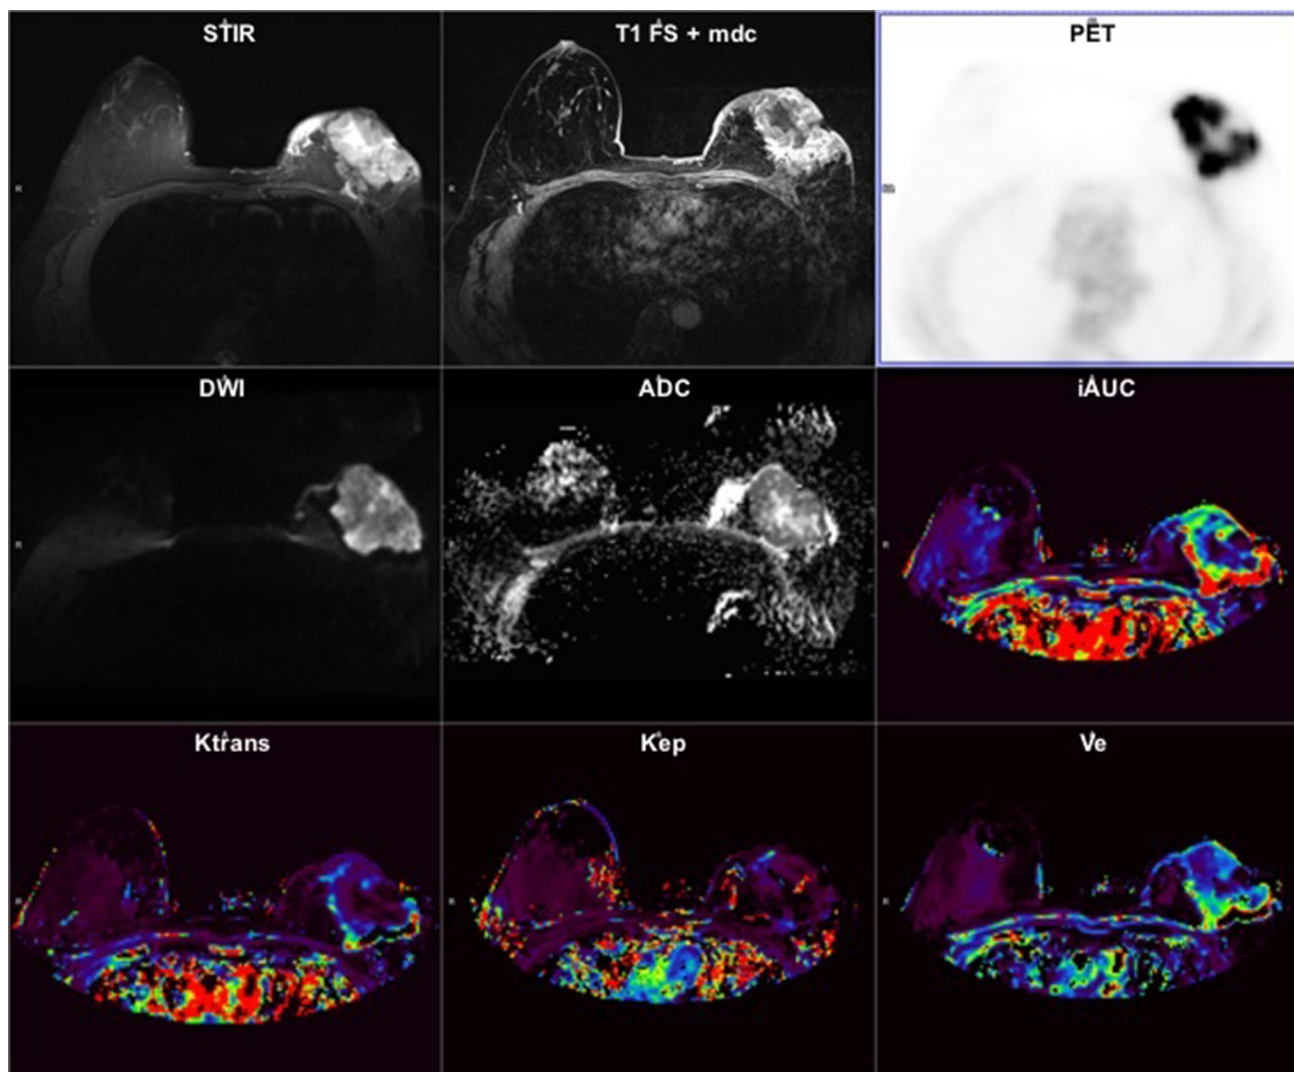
Multiparametric evaluation of morphological (STIR and T1 FS + mdc), metabolic (PET) and functional (DWI, ADC, iAUC, K_{trans} , k_{ep} , V_e) parameters in a 54-year old female (Pt 1) with an infiltrating ductal/lobular carcinoma of the left breast before cytotoxic
